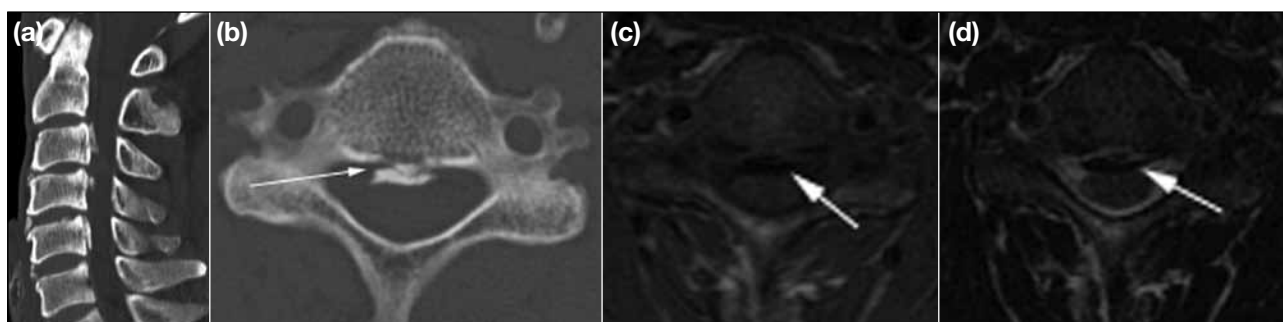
A 65-year-old male with thin ossification of the posterior longitudinal ligament (OPLL) that was missed by initial magnetic resonance. (a) Sagittally reconstructed computed tomography (CT) shows the segmental morphology of the OPLL. (b) Axial CT demonstrates the characteristic thin radiolucent line separating the ossified posterior longitudinal ligament from the posterior vertebral margin (white arrow). (c) T1-weighted axial and (d) T2-weighted axial sequences show the thin linear signal void that, in retrospect, represented the OPLL (white arrows). No abnormality was seen on the sagittal sequences (not shown).
